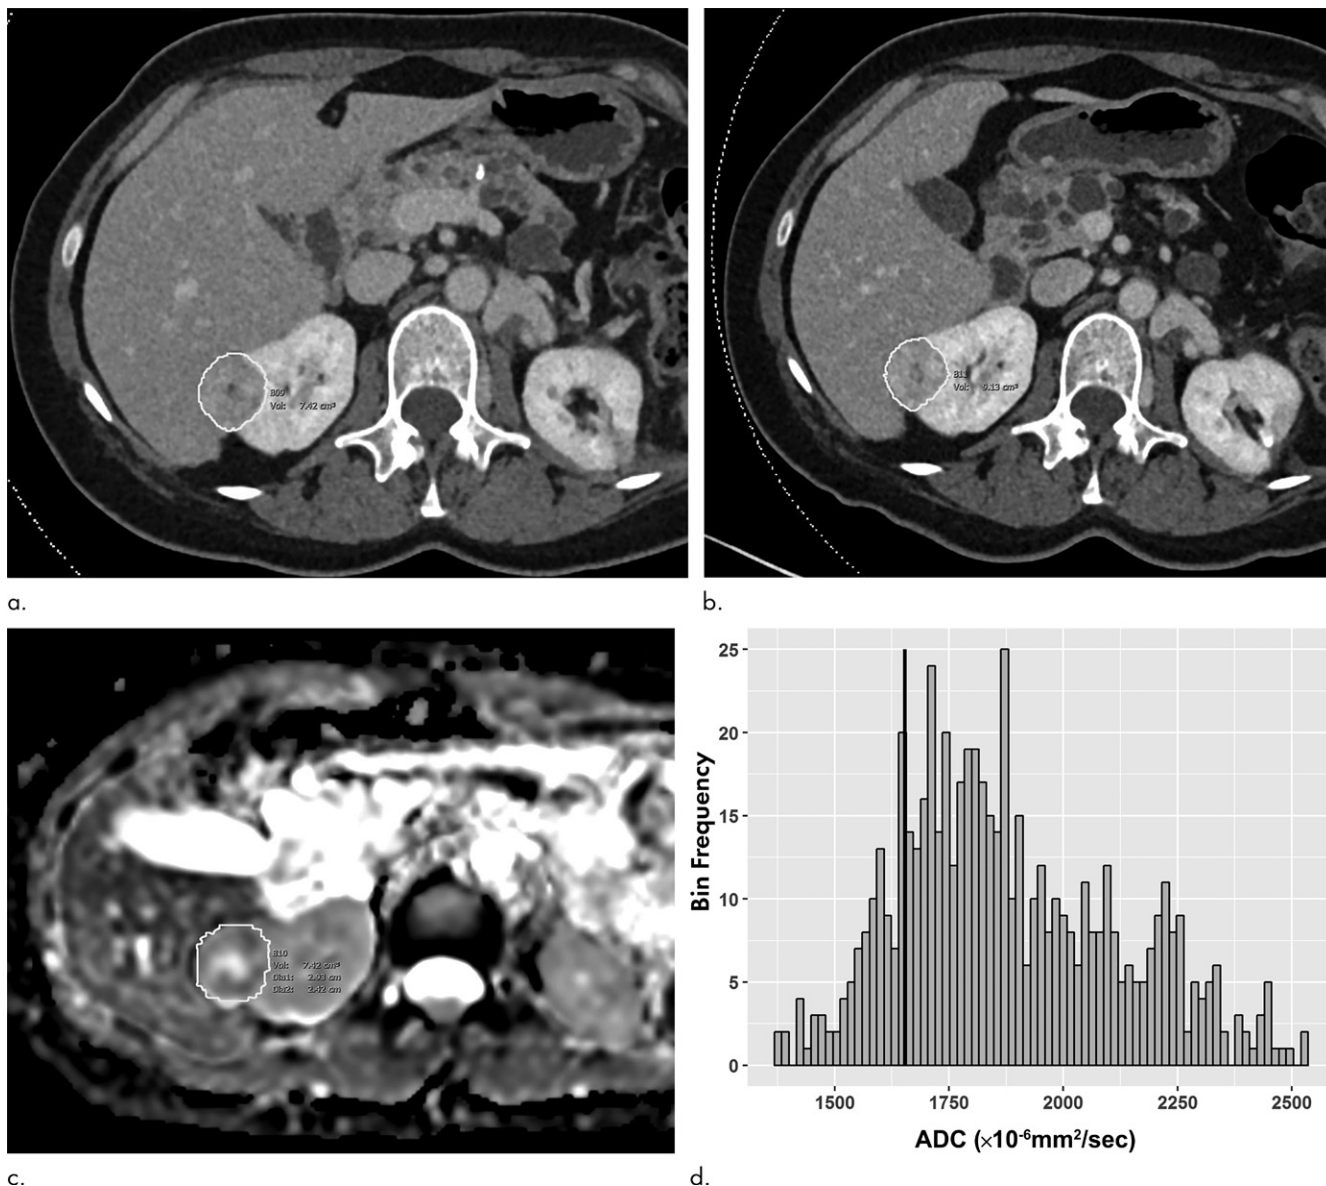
Images of clear cell renal cell carcinoma in a 55-year-old man with Von Hippel–Lindau syndrome. (a, b) Axial contrast material–enhanced nephrographic phase CT scans show the tumor was 7.4 cm³ at baseline (a) and had grown to 9.1 cm³ at 125 days (b). (c) Axial apparent diffusion coefficient (ADC) map of the tumor at baseline and (d) corresponding histogram percentile analysis.
